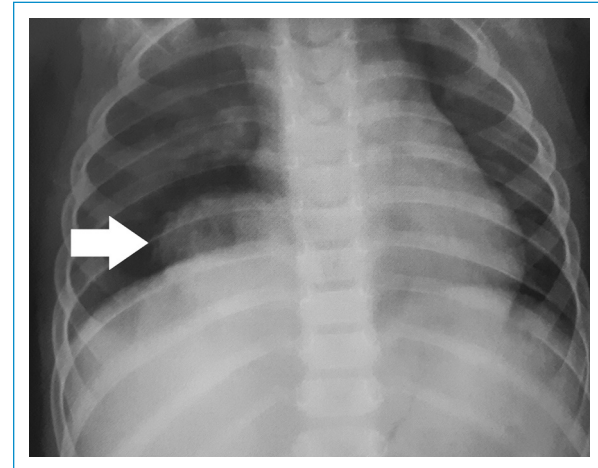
Chest X-ray in a posteroanterior view showing opacity in the right lung base (white arrow).
